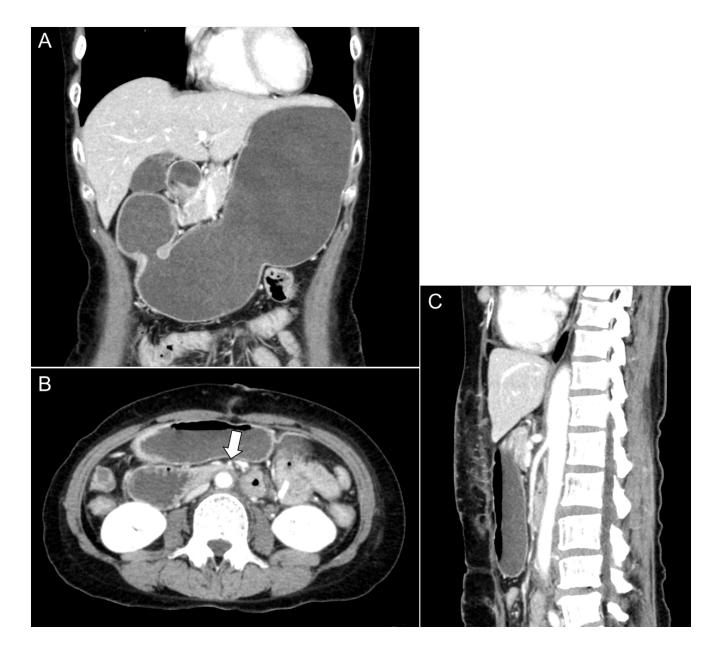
Enhanced computed tomography images of a 56-year-old female with superior
